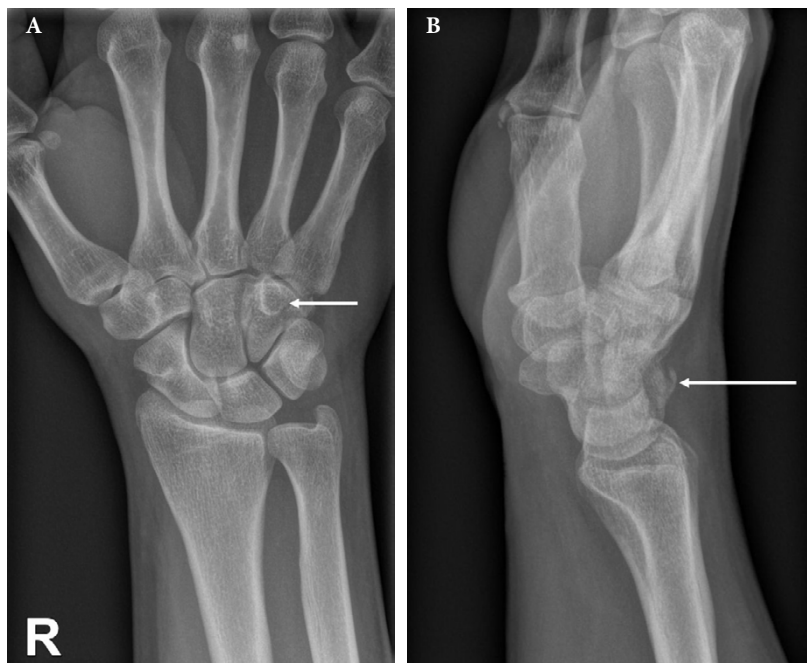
X-ray of the triquetrum bone (p-a view). A fracture of the dorsal cortex marked with an arrow.
